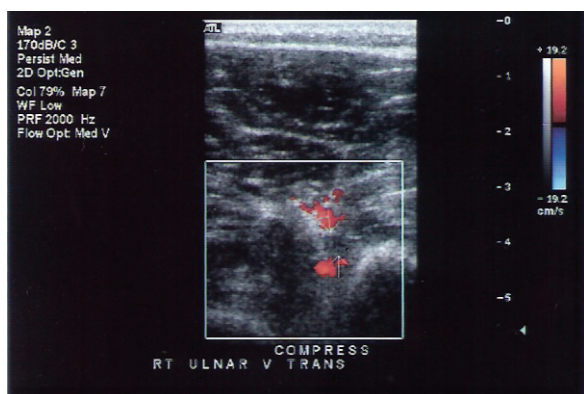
Cross-sectional venous duplex ultrasound of right midforearm. Small arrows outline the walls of the ulnar vein. Red indicates arterial flow toward the transducer. Blue indicates venous flow away from the transducer. Lack of venous flow and incompressibility demonstrate acute deep venous thrombosis.
